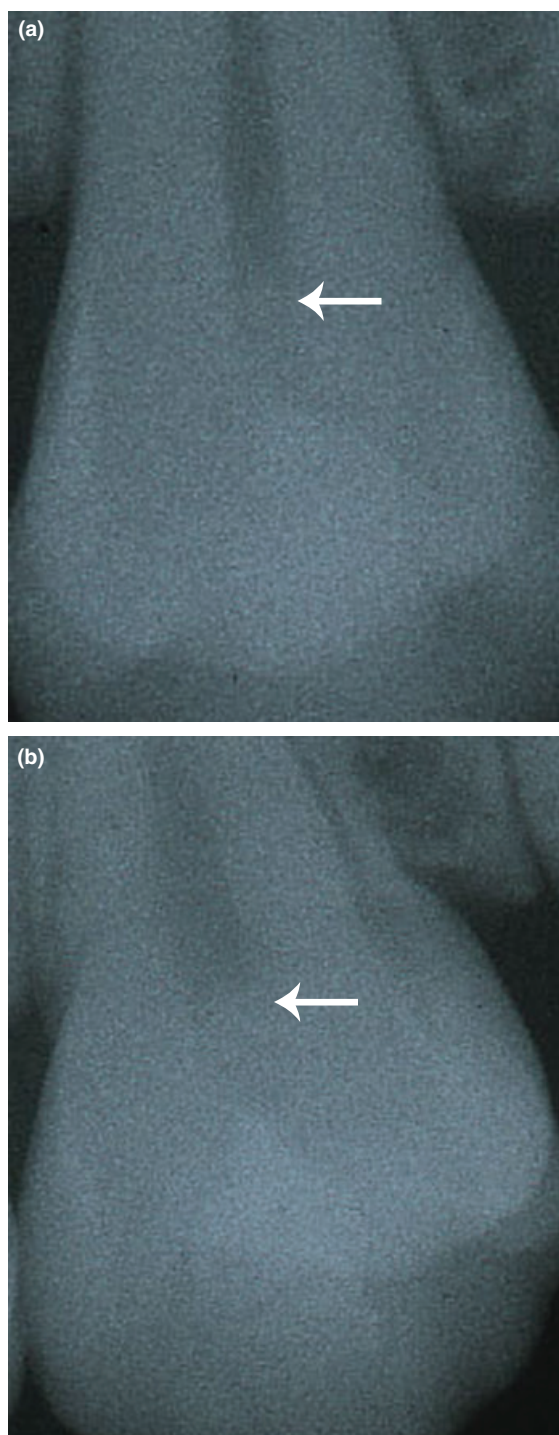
Radiographs taken at 6 months suggesting the presence of dentin bridge (arrow) under the capping material in Ca(OH)_2 -treated tooth (a) and EMDgel-treated tooth (b).
